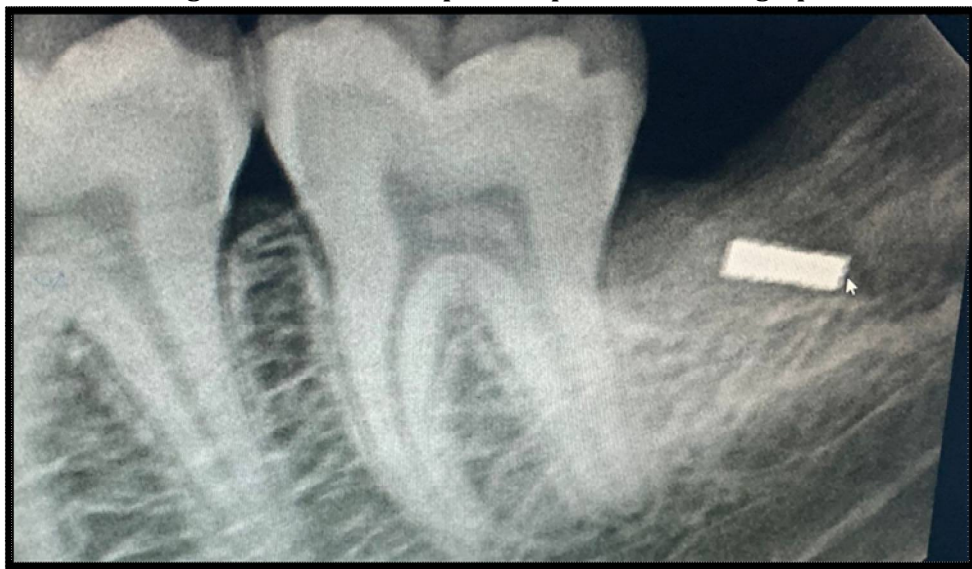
Intra-Oral Periapical view radiograph showing the bur fragment in the socket of the left mandibular third molar.
